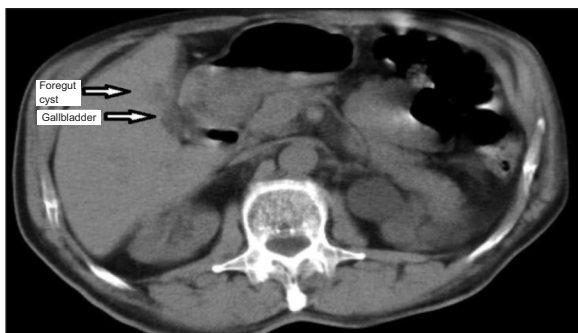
Computed tomography revealed a cystic structure adjacent to the gallbladder wall.
